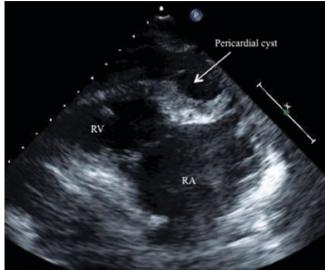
Echocardiography parasternal long axis view showing a pericardial cyst, anterior to the right heart chambers (courtesy of MS. Cohen, MD). RA right atrium, RV right ventricle
